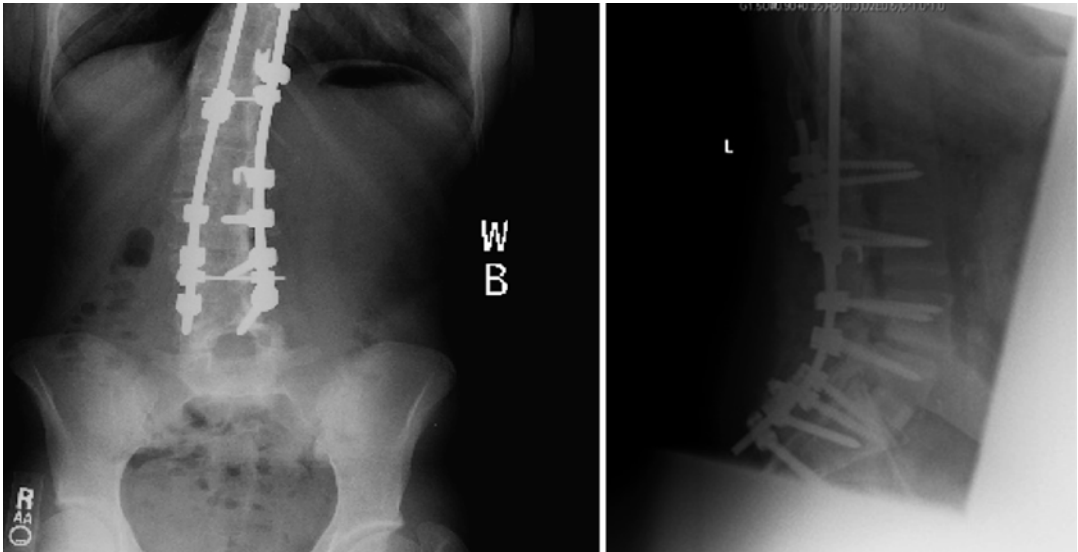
AP and lateral standing lumbar radiographs demonstrating high-grade spondylolisthesis and previous fusion for scoliosis
